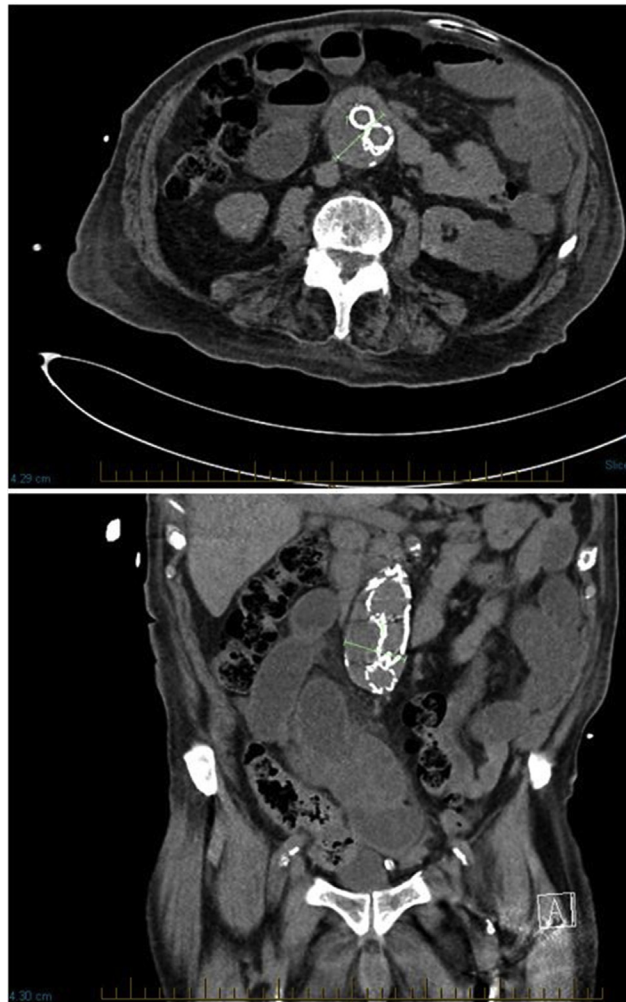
Computed Tomography Angiography Before Transcatheter Aortic Valve Regurgitation
